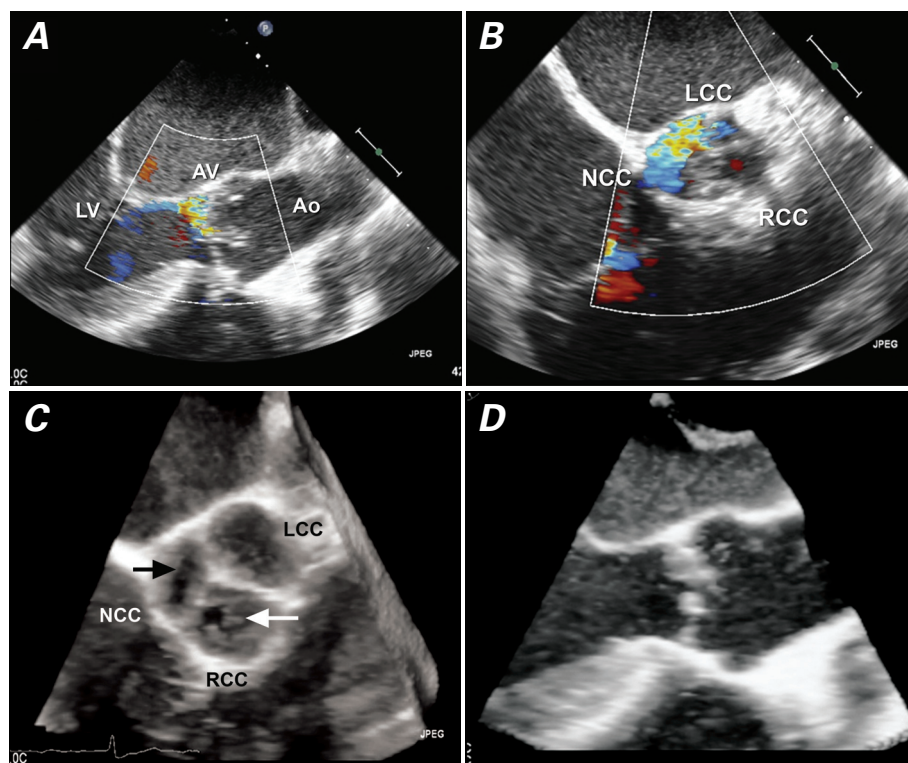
Two-dimensional transthoracic echocardiograms with color-flow Doppler in A) long-axis and B) short-axis views show eccentric aortic valve regurgitation. C) Three-dimensional transesophageal echocardiogram (short-axis view) of the aortic valve in diastole reveals major perforations in the right coronary and noncoronary cusps (arrows) and multiple small perforations in the left coronary cusp. D) Three-dimensional long-axis view shows moderate thickening, consistent with previous endocarditis.
